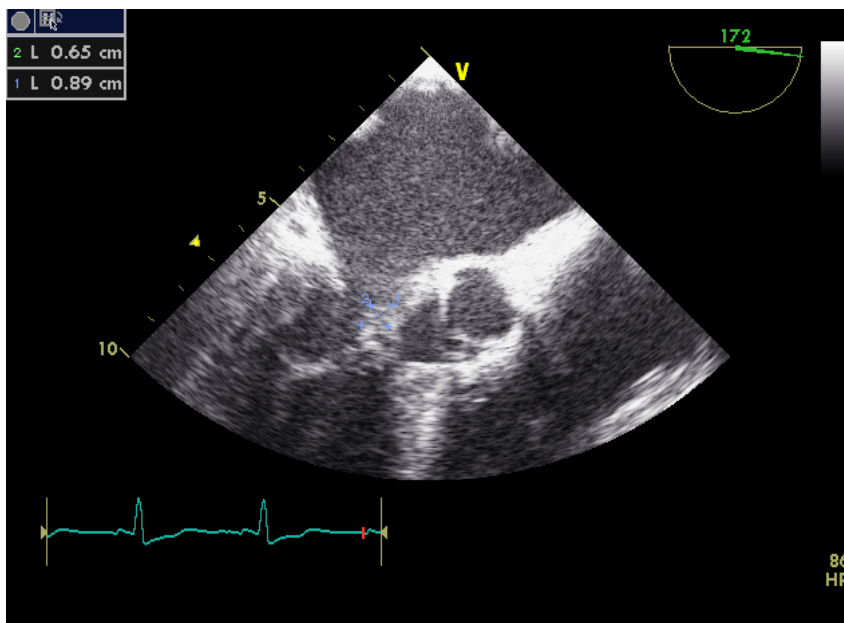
Transesophageal echocardiographic report showed preserved left ventricle systolic function without significant wall motion abnormality. Besides, report showed calcified aortic leaflet with mild to moderate aortic regurgitation without aortic stenosis. One vegetation (0.65 x 0.89cm) was recorded over anterior mitral leaflet
